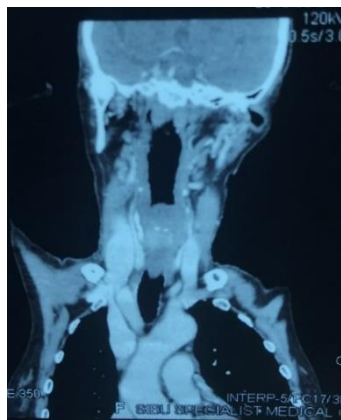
Coronal view of CT
